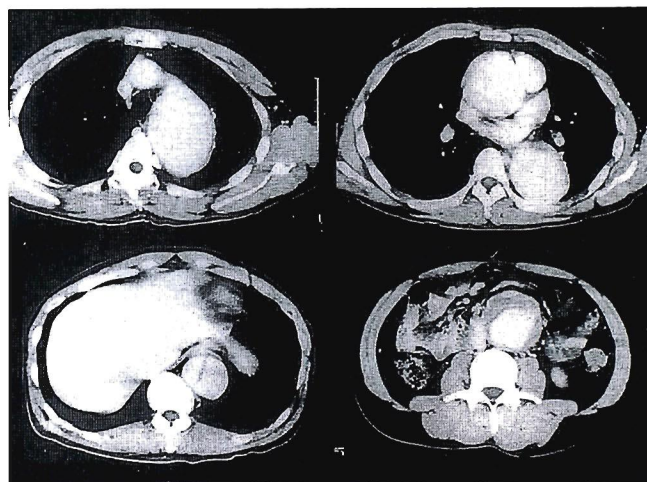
Computed tomography (CT) finding of an aortic aneurysm. Diffuse aneurysmal dilatation with dissection is seen from the ascending to abdominal aorta.
